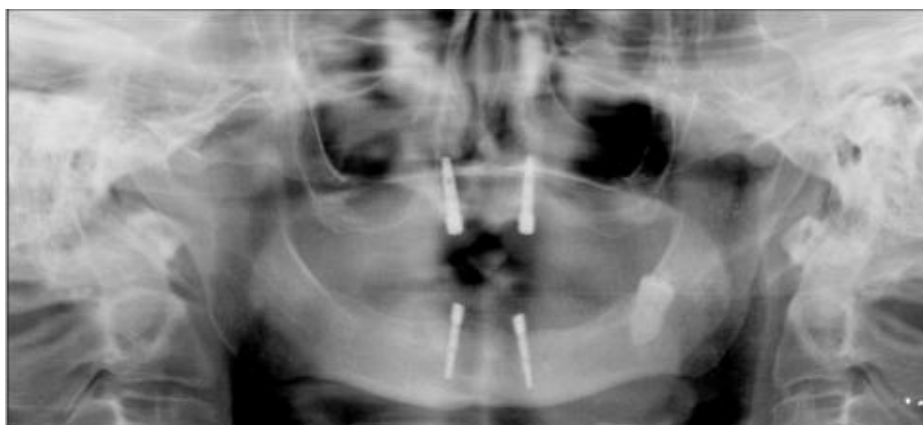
Panoramic radiograph of the endosseous dental implants in the maxilla and mandible.
